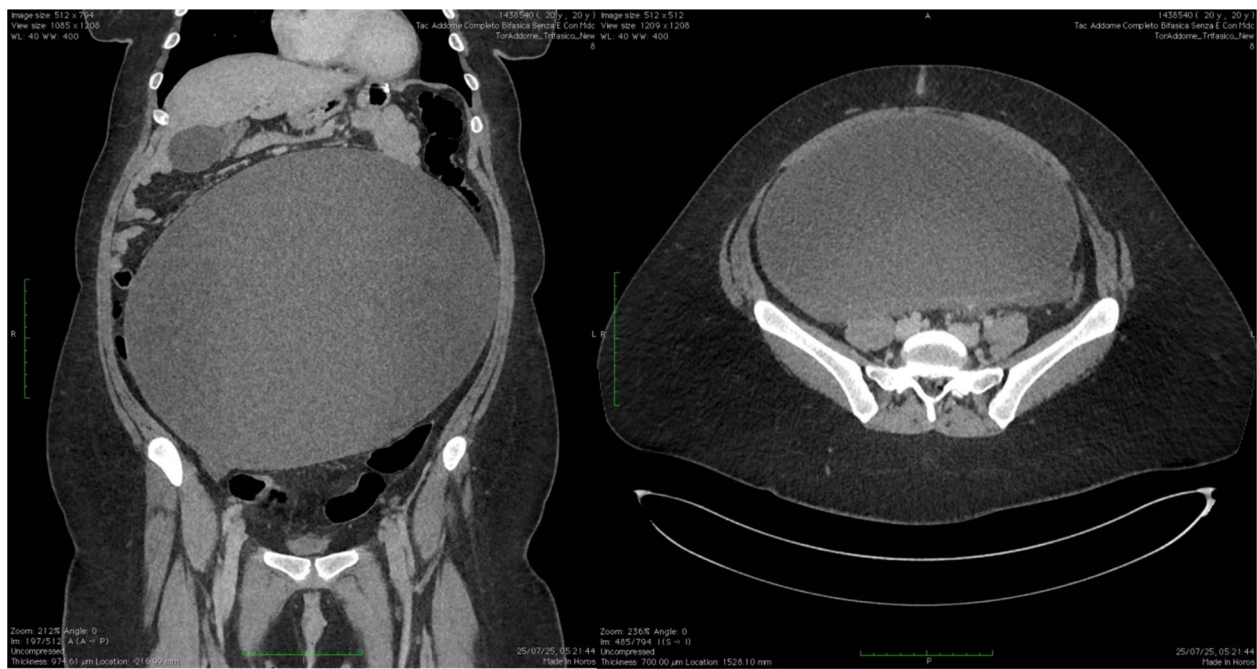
CT scan showing ovarian cyst compressing the small bowel in the epigastrium (longitudinal and transversal section).
